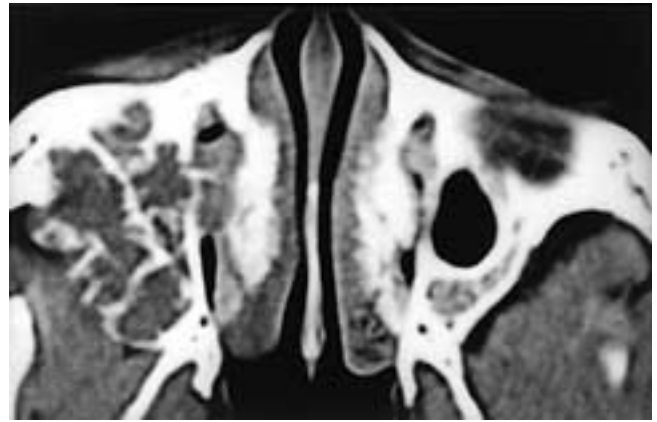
Axial CT scan shows a partially destructive and partially expansile mass in the right maxillary sinus. The lesion contains lacelike areas of calcification. This patient had a fibromyxoma.
